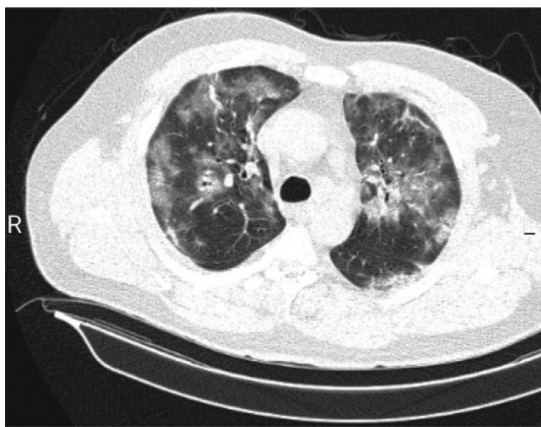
Chest CT scan without contrast showing COVID-19 pneumonia.
